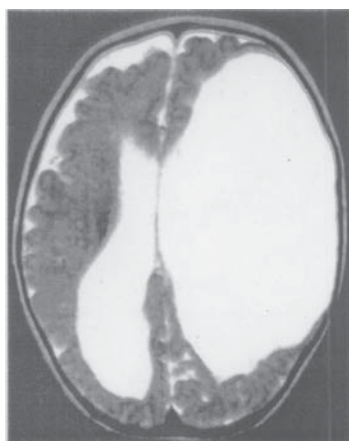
Axial T2W MR images shows a large porencephalic cyst in the left cerebral hemisphere.
